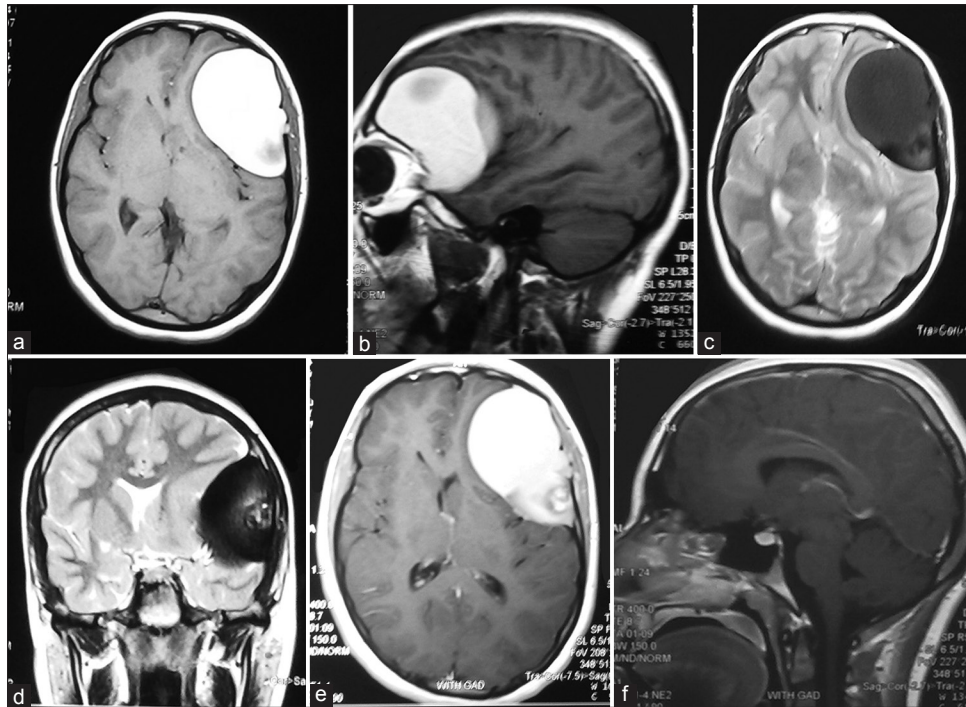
Magnetic resonance imaging studies showing an extra axial heterogeneous mixed solid and cystic mass at the left frontal and temporal areas. (a) Axial T1-weighted magnetic resonance imaging and (b) sagittal T1-weighted magnetic resonance imaging exhibiting a high signal intensity extra axial mass. (c) Axial T2-weighted magnetic resonance imaging and (d) coronal T2-weighted magnetic resonance imaging showing a hyposignal to isosignal mass. (e) Axial T1-weighted magnetic resonance imaging with gadolinium showing no remarkable enhancement after contrast administration. (f) In sagittal T1-weighted magnetic resonance imaging with gadolinium sellar and suprasellar region appear normal
